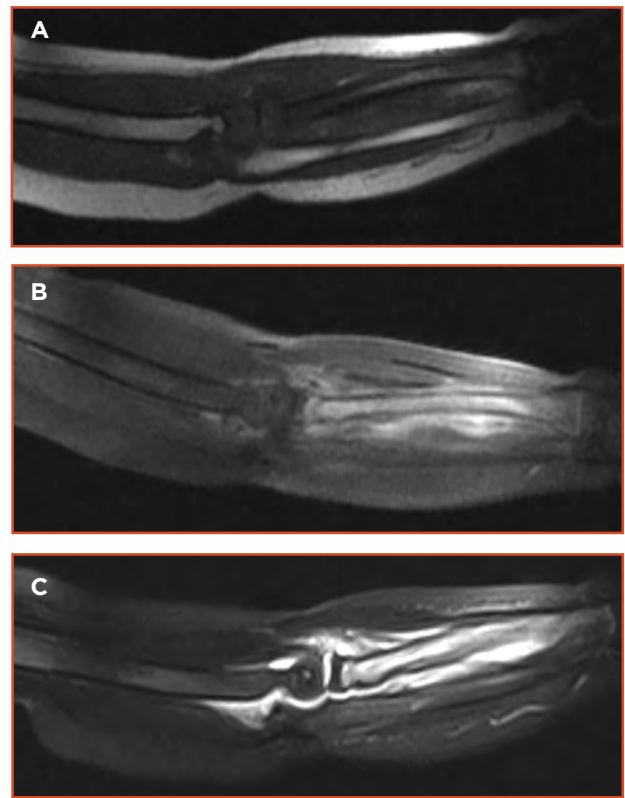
A) T1-weighted, pre-contrast sequence of magnetic resonance imaging showing hypointensity in the proximal radius. B) Hyperintense signal on post-contrast T1 sequences in the proximal radius and surrounding soft tissues, suggestive of osteomyelitis. C) Sort T1-inversion recovery sequences also showing a hypointense signal.
